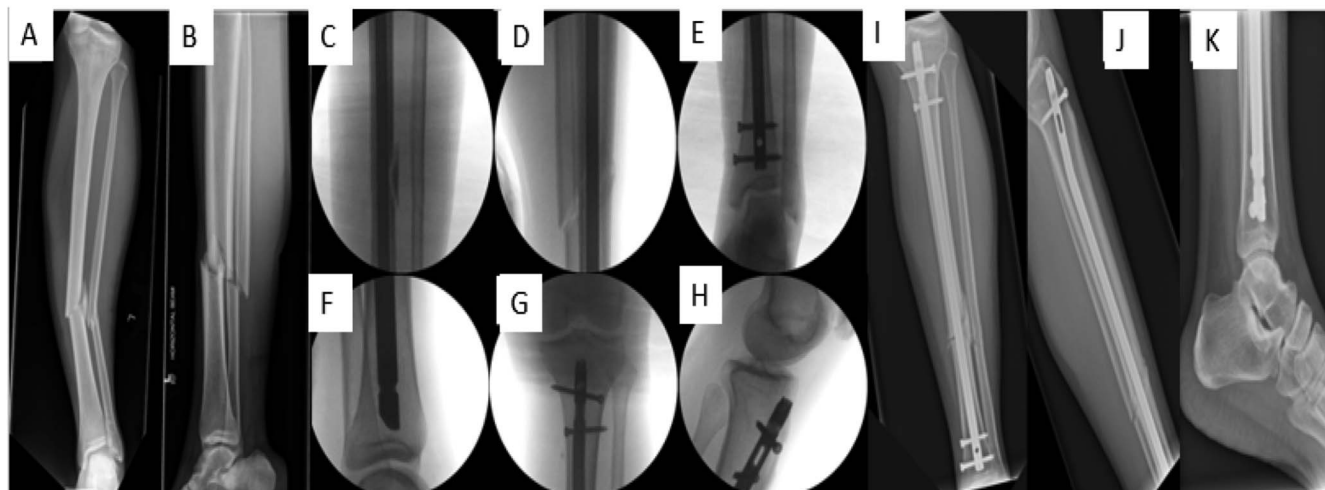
A 24-year-old woman sustained a road traffic collision and suffered an open tibial shaft fracture. A and B, Preoperative tibia radiographs demonstrating the fracture. C, D, E, F, G, and H, Intraoperative fluoroscopic images showing the stabilization of the fracture with the Bactiguard-coated natural nail. I, J, and K, Postoperative radiographs showing the fracture union 3 months postoperatively.
